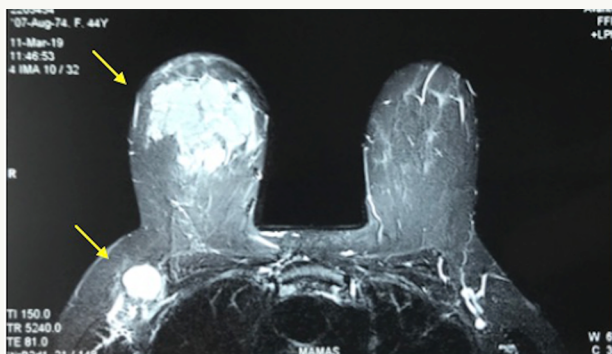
Breast magnetic resonance image (MRI)
